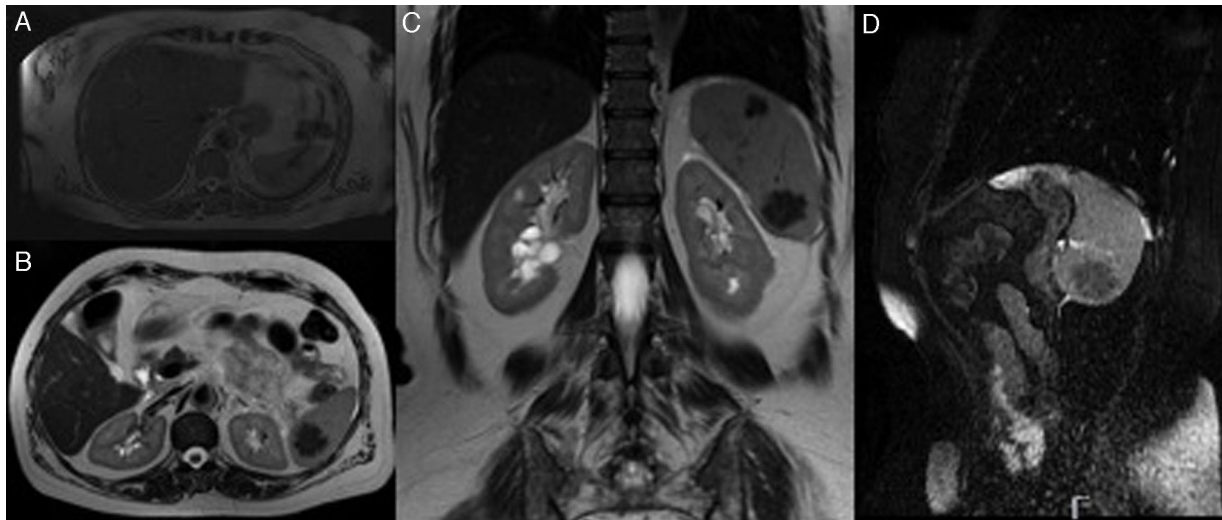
Magnetic resonance imaging. (A) T2-weighted sequences (axial plane) showing a vascular structure in the splenic hilum with a nodular configuration. A macronodular lesion is also seen in this image, within the spleen, exhibiting low signal. (B and C) T2-weighted sequences (axial and coronal plane, respectively) showing nodular lesions, in the upper spleen and the lower spleen, with lobular borders, hypointense, sketching internal micronodular formations. (D) Fiesta FATSAT (sagittal plane) sequence showing a hypointense lesion in the lower spleen, with discrete hyperintense septa.
